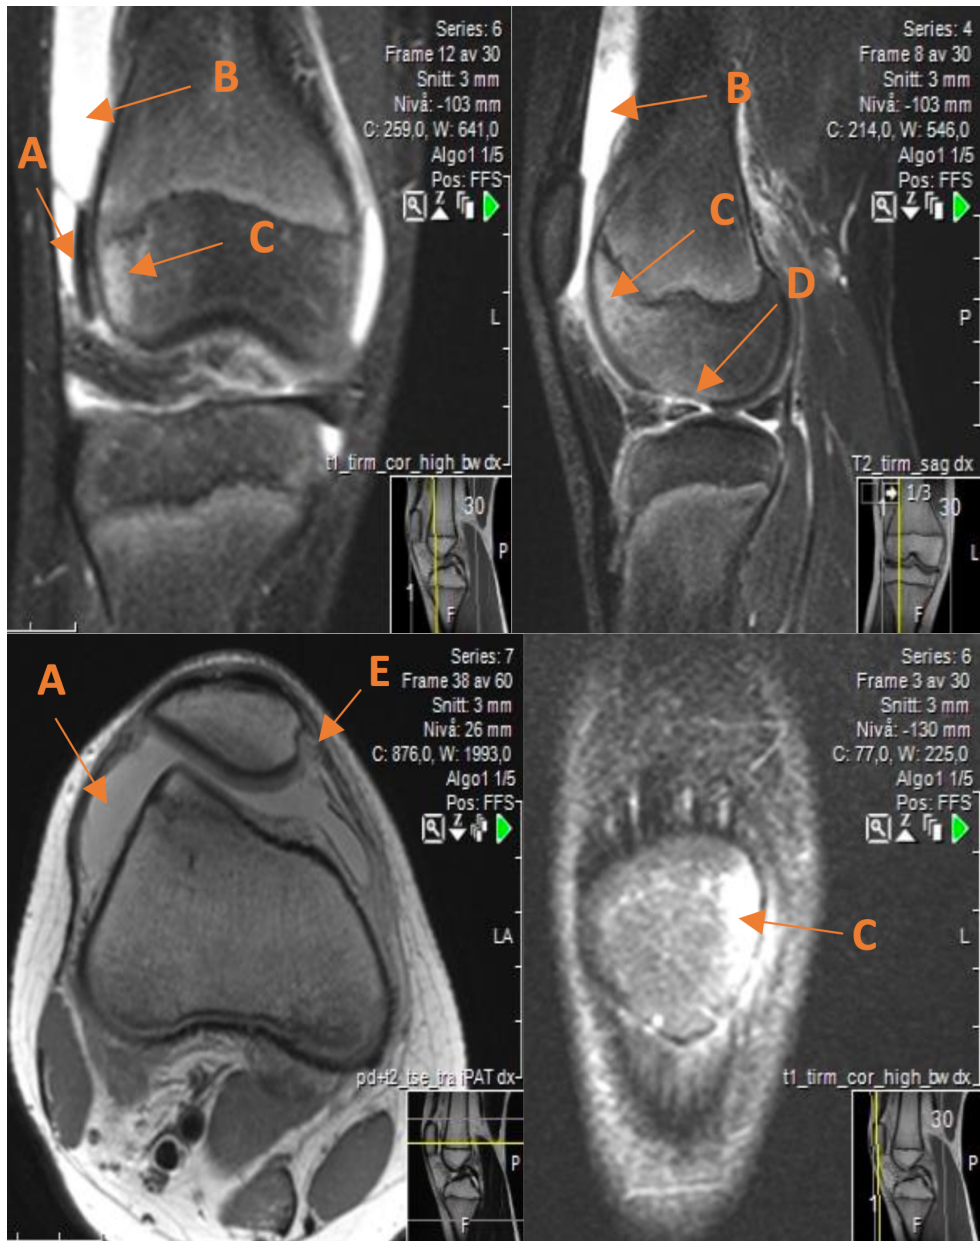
Typical MRI signs of LPD with an osteochondral fracture
